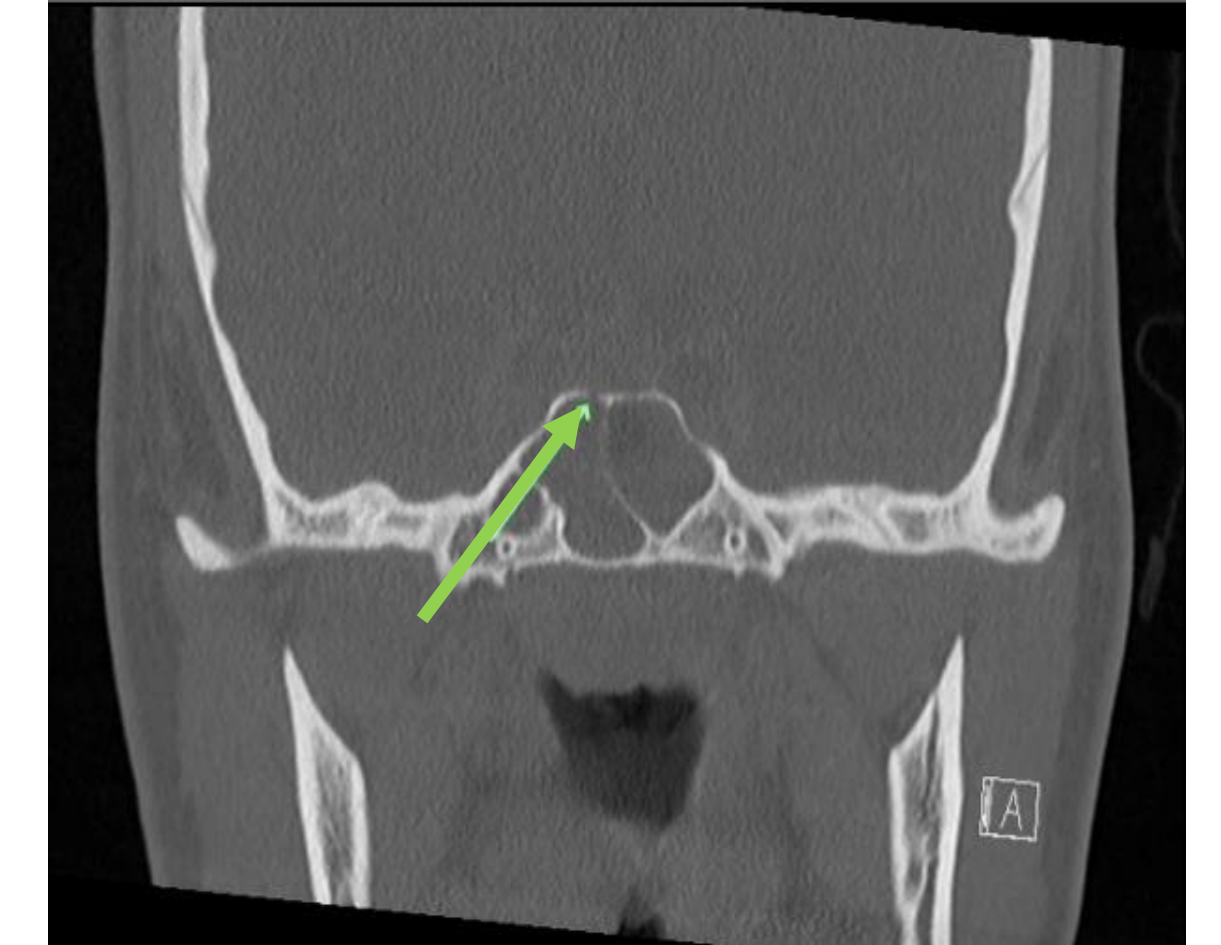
CT Sinus with contrast, coronal cut, sphenoid sinus disease with bony dehiscence along superior right sphenoid sinus (arrow)
